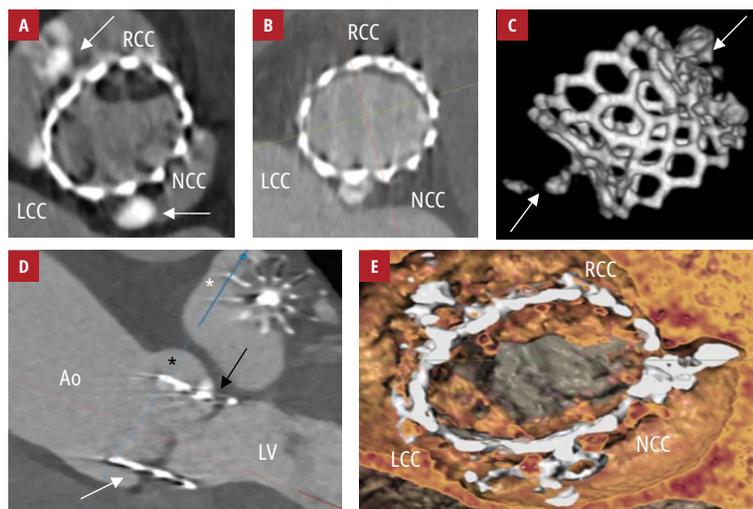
Multislice computed tomography images at 4 months: A – a bioprosthesis with severe residual calcium deposits (arrows) and hypoattenuated thickening of the left and right leaflets; B – an elliptical shape of the bioprosthesis at the inflow level; C – volume rendering reconstruction demonstrating bioprosthesis frame distortion and massive residual calcium deposits (arrows); D – longitudinal reconstruction showing thickening of the right (white arrow) and left (black arrow) leaflets as well as enlarged native sinuses (black asterisk). The Watchman device is also seen in the left atrium (white asterisk); E – *en face* projection showing maximal systolic leaflet opening and immobile left and right leaflets
